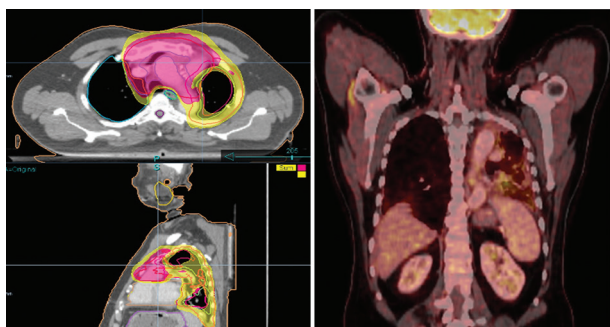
Hemi-thoracic radiotherapy for a patient with stage IVA thymoma, with corresponding post-treatment fibrotic changes observed on follow-up positron emission tomography-computed tomography scan
